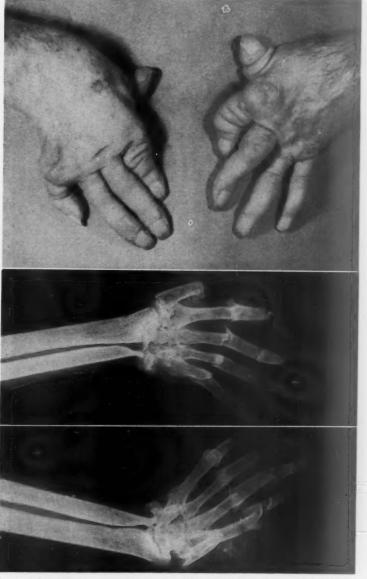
A. (above) Photograph of hands (case 3). B. (below) X-rays of hands (case 3).
